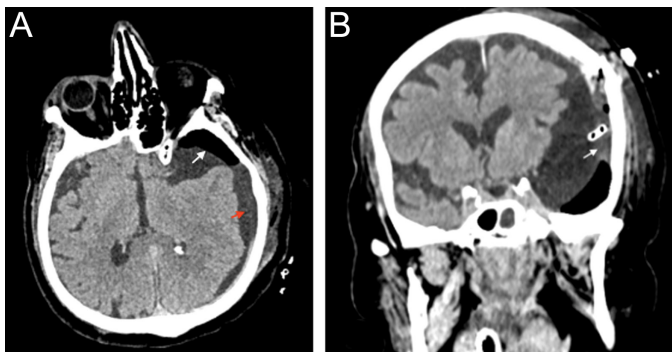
Postoperative computed tomography images after burrhole craniostomy: (A) Axial computed tomography: moderate subdural hypodense collection (red arrow) and post-operative extra-axial pneumocephalus (white arrow). (B) Coronal computed tomography: The border of arachnoid cyst adjacent to the subdural collection (white arrow).
